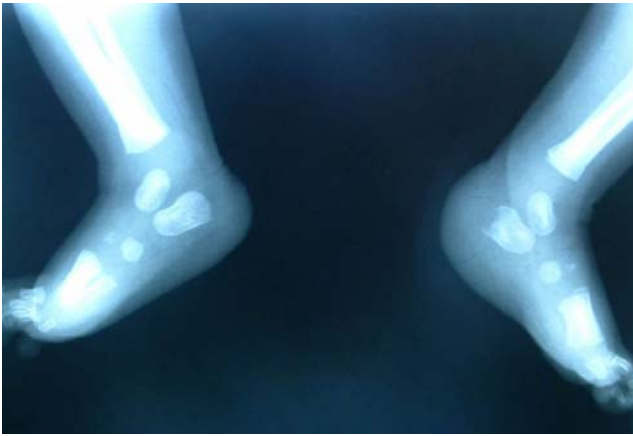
Lateral radiograph of the left foot showing soft tissue swelling of the heel and focal bone destruction as finding osteomyelitis of the calcaneus
